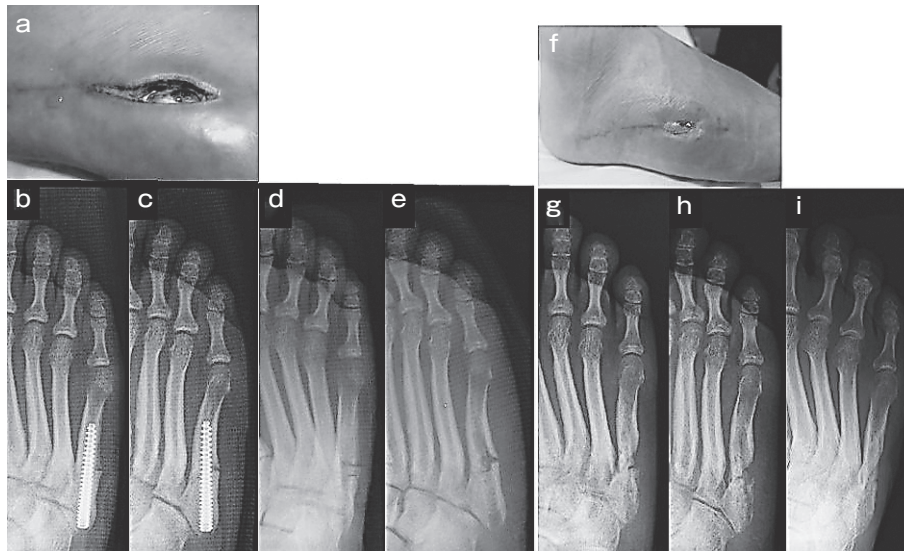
photograph of right foot (a), osteomyelitis occurred; A-P (b) and oblique (c) of foot X-ray 2 months after operation; A-P (d) and lateral (e) of foot X-ray, The screw was removed, and curettage was performed 3 months after operation; photograph of right foot (f) and A-P (g) and oblique (h) of foot X-ray, Infection subsided, and the wound closed 6 months postoperatively; A-P (i) of foot X-ray 2 months after operation; A-P (d) and lateral (e) of foot X-ray, The patient had not achieved bone union one year after operation.
